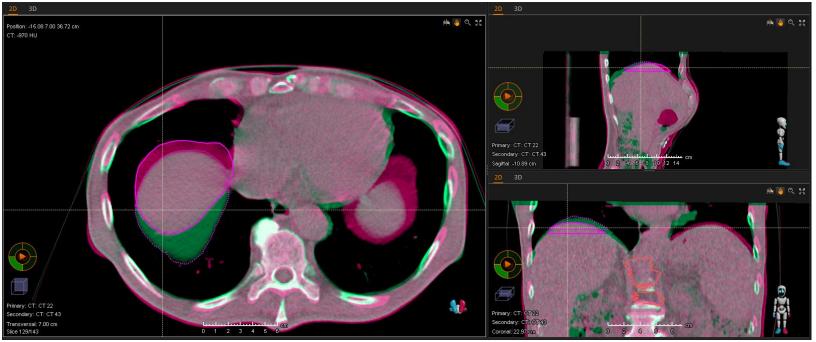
HCC patient. Clinical carbon ion plan optimized on GTV (blue contour) on planning CT at 0EX phase (red). Re-evaluative pretreatment CT at corresponding phase is registered on it (green) and GTV is warped (dotted blue line), Treatment within the selected breathing range could not be guaranteed in this case, given this difference at full expiration phase. GTV DVHs for plan (blue) vs recalc. (light blue) is provided.
